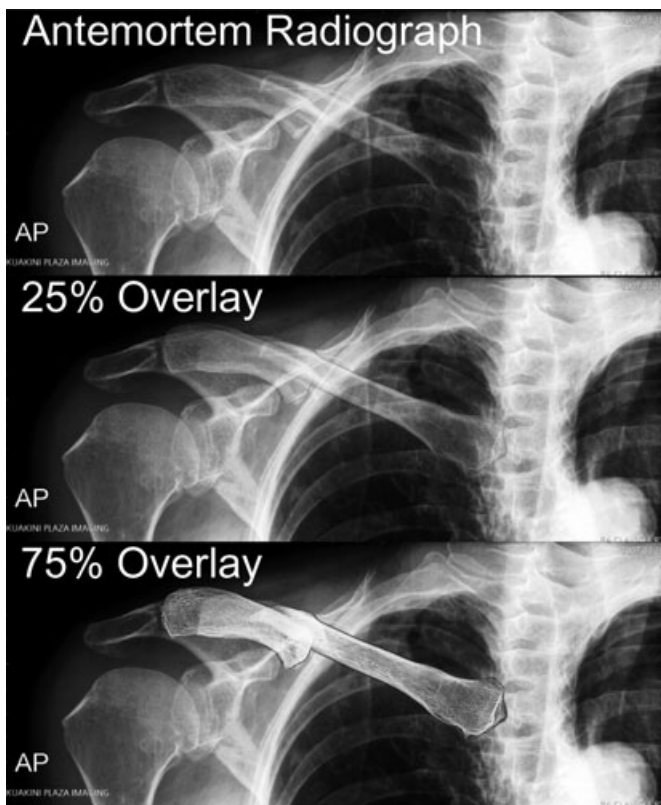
Antemortem radiograph, 25%, and 75% postmortem radiograph overlays.
